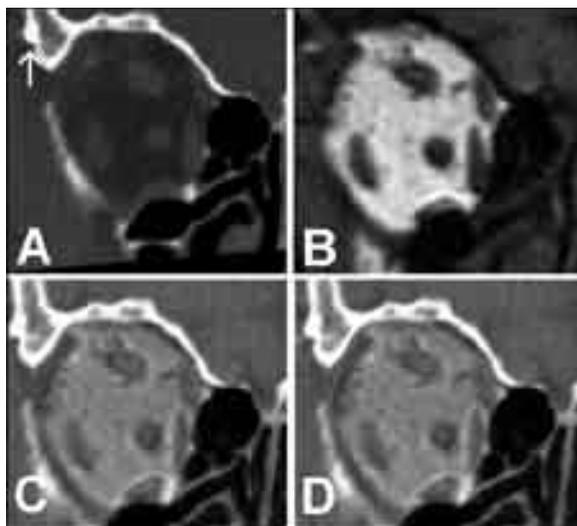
Patient C.S. Frontal CT (a) and MRI T1-weighted (b) scans through the orbits after bone fragment reposition and application of polypropylene fabric into the right orbit to cover the bone defect in the lateral wall. Alloplastic material is not visible. Arrow indicates place of typical titanium plates and screws used for osteosynthesis. c: CT/MRI fusion. d: Fused image: red line indicates place of the fabric implantation on the lateral wall.
